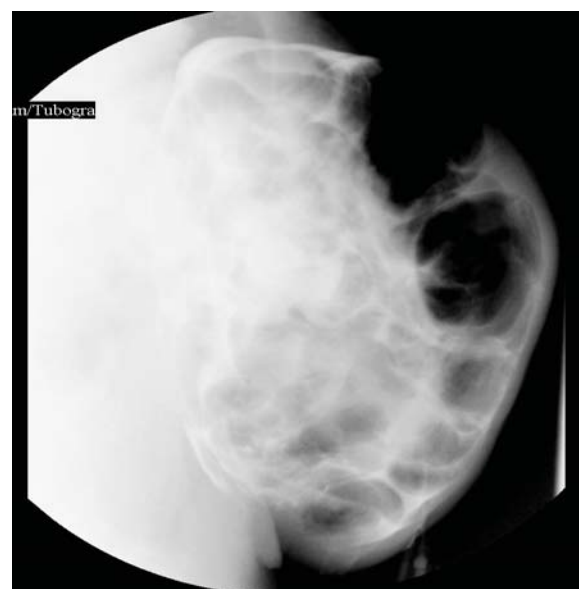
Lateral view of sonogram.
